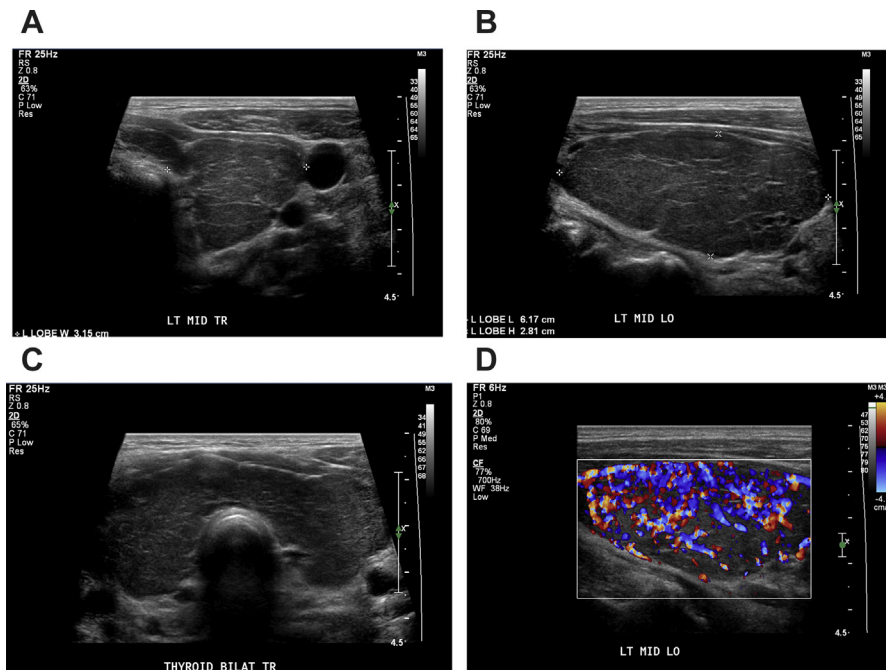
A 42-year-old woman with Graves disease. (A–C) Enlarged, mildly heterogeneous gland with decreased echotexture, and a scalloped, nodular contour without focal nodules on gray-scale. (D) Increased color Doppler flow due to hyperemia is shown in the left lobe, longitudinal plane. Cursors on (A, B) represent thyroid lobe measurements in the transverse and longitudinal planes.
